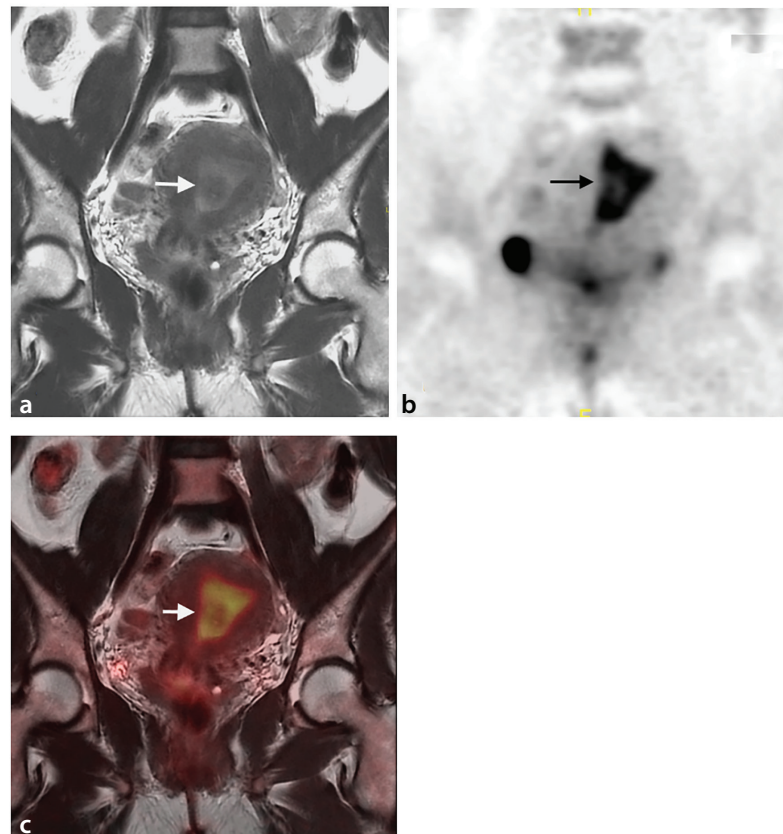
Menstrual endometrial uptake. The coronal T2-weighted image (a) shows the endometrial cavity containing hypointense blood products (arrow). The coronal maximum intensity projection fluorodeoxyglucose (FDG) positron emission tomography (PET) (b) and coronal fused PET/magnetic resonance (c) images demonstrate increased FDG uptake in the endometrium (arrows), consistent with menstruation-related physiological activity in a 41-year-old premenopausal woman.
